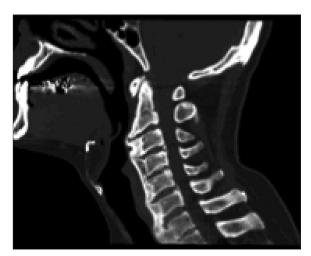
Sagittal cervical CT scan - Bone window
